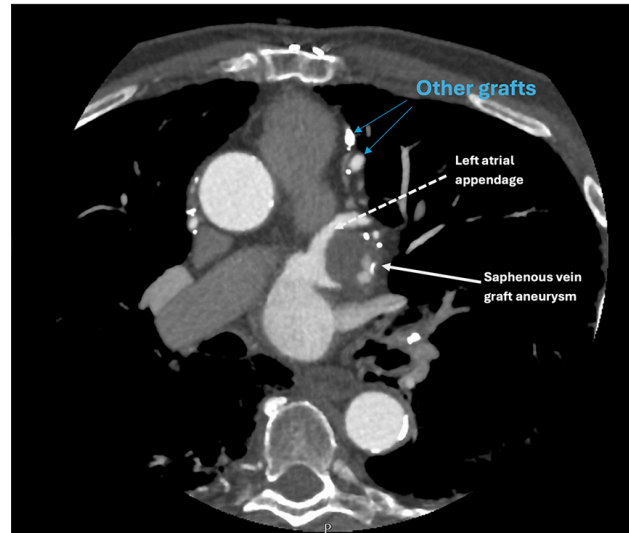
A 85-year-old man with back pain, constipation, and generalized fatigue with a history of coronary artery bypass grafting. Axial contrast-enhanced cardiac computed tomography angiography demonstrates the mass' relationship with the left atrial appendage and reveals the mass to have a partially thrombosed lumen. Another patent saphenous vein graft is noted anteriorly. (White arrow: Saphenous vein graft aneurysm, Dashed arrow: Left Atrial appendage, Blue arrow: Other grafts).
